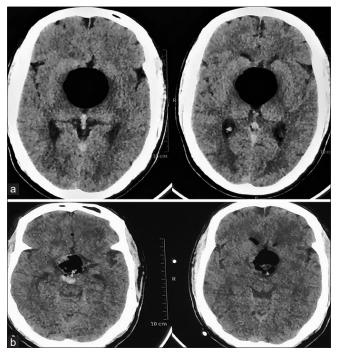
On the postoperative day 3, the patient developed severe headache and sudden visual deterioration. CT of the head (a) demonstrates suprasellar tension pneumatocele. The patient underwent emergent endoscopic exploration and revision of the skull base repair was performed to obliterate a ball-valve fistula. (b) Postoperative computed tomography (CT) demonstrates resolution of the tension pneumatocele
